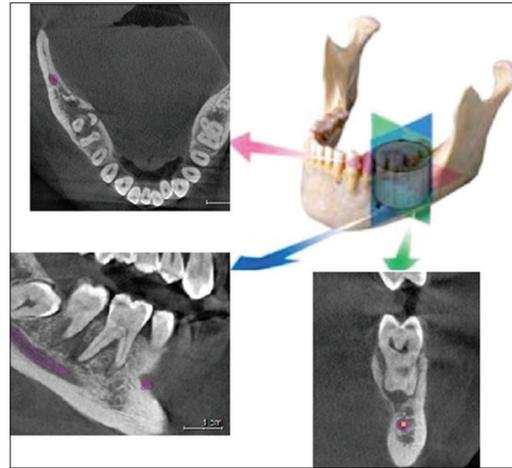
Standard display modes of cone beam computed tomography volumetric data in the axial, sagittal, and coronal plane
